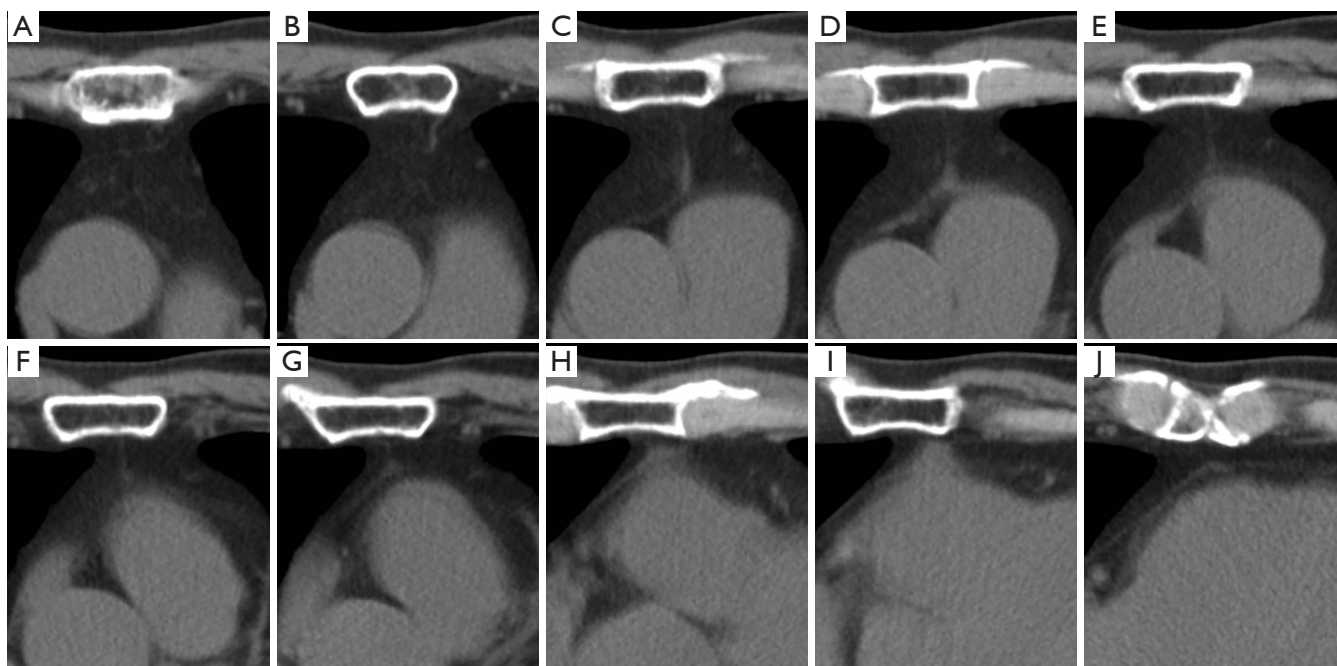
Typical images of the sternopericardial ligament on chest computed tomography. The sternopericardial ligament is shown as a line between the sternum and pericardium. (A) At the manubriosternal joint, the capsule of the thymic lobes is slightly visible, but no other findings are apparent. (B) A line appearing on the left side of the sternum. (C) A line runs toward the pericardial sac and is thicker in the thymic glands. (D) A triangular shadow was observed where the vertical line contacted the pericardium. A small, firm, white nodular strip is often observed surgically. (E-G) A thin line connecting the sternum and pericardium, and the figure is indistinct in contrast to the upper area. (H-I) The pericardium contacting the sternum is thick and adhesions are surgically observed here. In the supine position, the pericardial sac was deformed by being pulled up in the ventral direction owing to the adhesion. (J) Below the sternal body, near the xiphoid process, and the pericardial fat was between the chest wall and pericardium.
